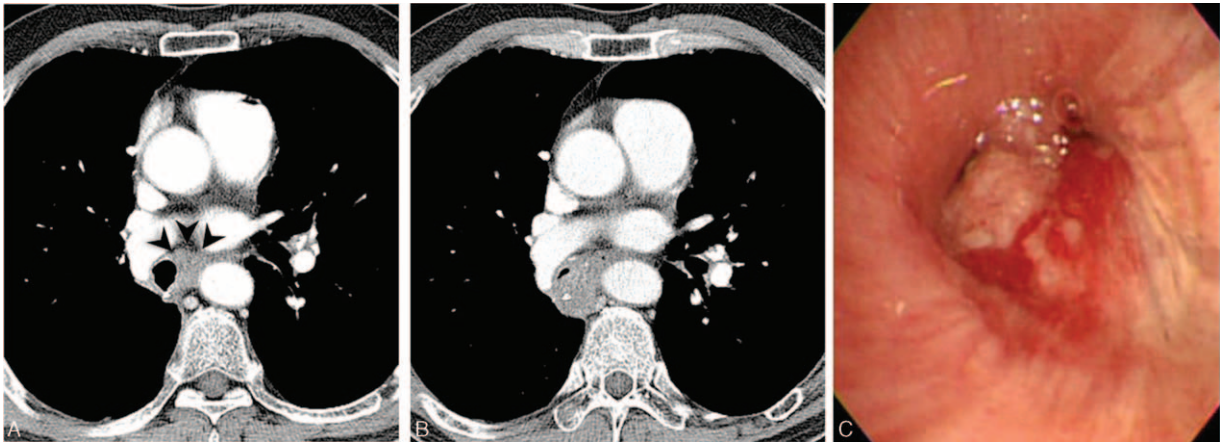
A 68-year-old man with tumor recurrence after right lower lobectomy for squamous cell lung in left lower lobe (pT2,N1,M0). A, On postoperative transverse CT image (3-mm thickness reconstruction) shows peripheral eccentric soft tissue with heterogeneous enhancement at the medial side of bronchus intermedius with 15 mm size and 7 mm in the distance between lesion and stump (arrowheads). It was missed on the routine radiologic diagnosis. B, 7 months later, follow-up CT (3-mm thickness reconstruction) at the same level shows the interval growing of the enhancing soft tissue and narrowing of the bronchus intermedius. C, Bronchoscopic image shows endobronchial obstructing mass at bronchus intermedius. Recurrent cancer was revealed on bronchoscopic biopsy.
